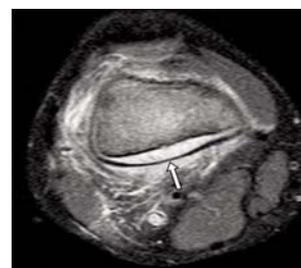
Subperiosteal fluid (probably hemorrhage) is shown by the arrow on an axial MRI section of the patient's right knee.
